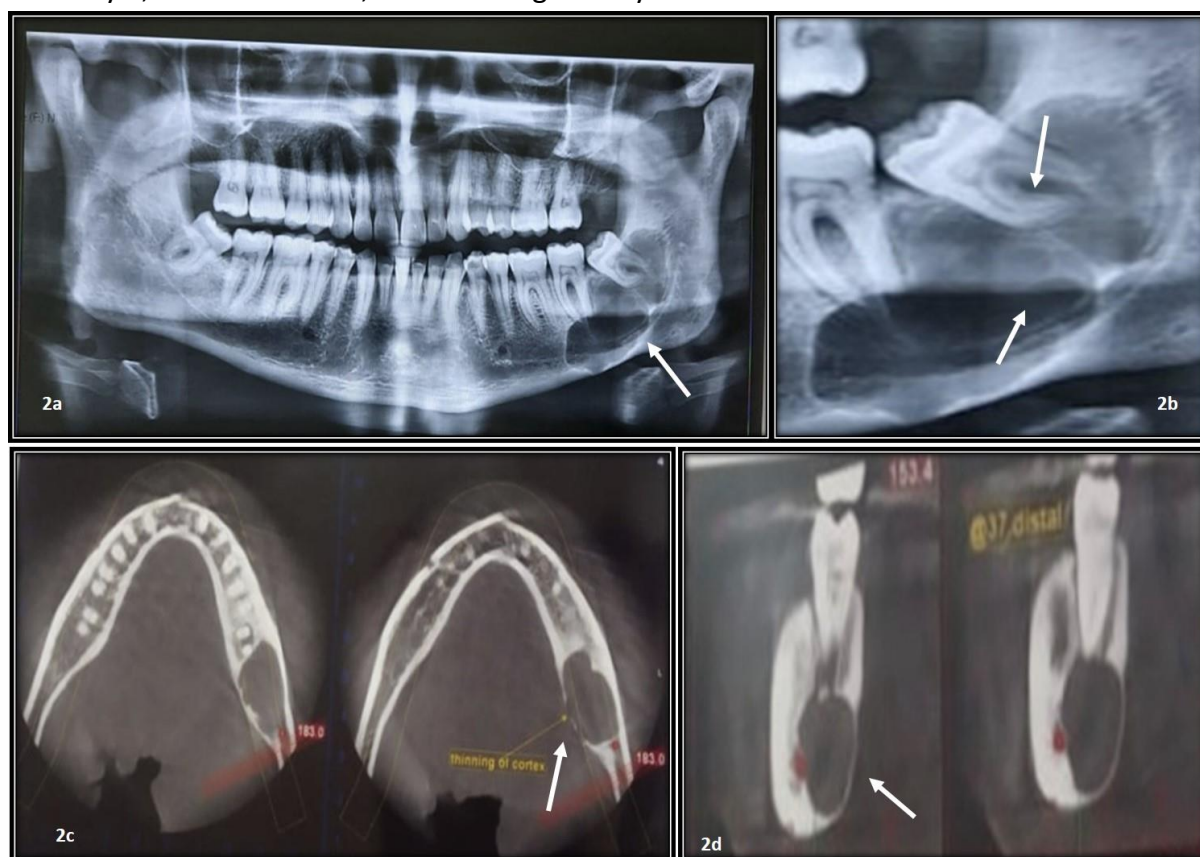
a. OPG shows a well-defined multilocular radiolucency with scalloped and corticated borders in periapical area of 37 and 38. Figure 2.b. OPG-cropped image showing soap bubble appearance with dilacerated mesial root of 38. Figure 2.c. CBCT in Para-axial section shows thinning and perforation of lingual cortex along with the displacement of mandibular canal towards the buccal cortex. Figure 2.d. CBCT in Axial image showing the well-defined hypodense area with scalloped corticated border in relation to 37.
